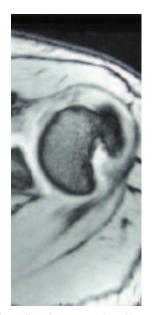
MRI revealing a large postero-lateral humeral head defect.
